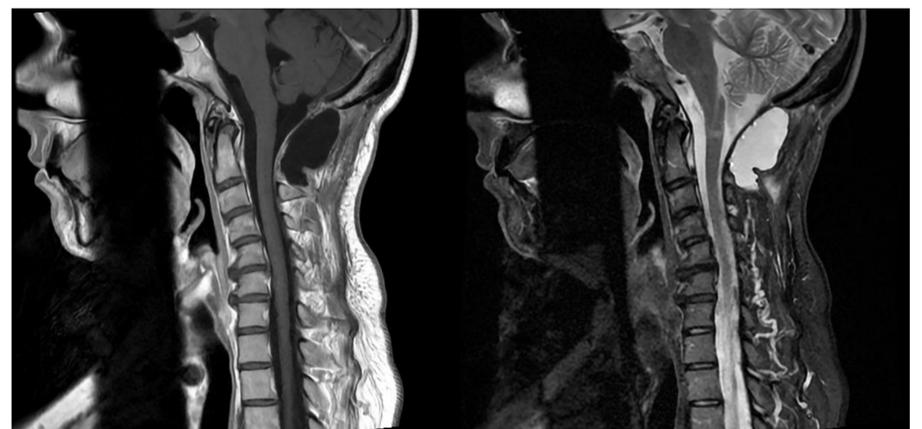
Postoperative sagittal contrast-enhanced T1-weighted (left) and T2-weighted (right) MRI demonstrating gross total resection.
